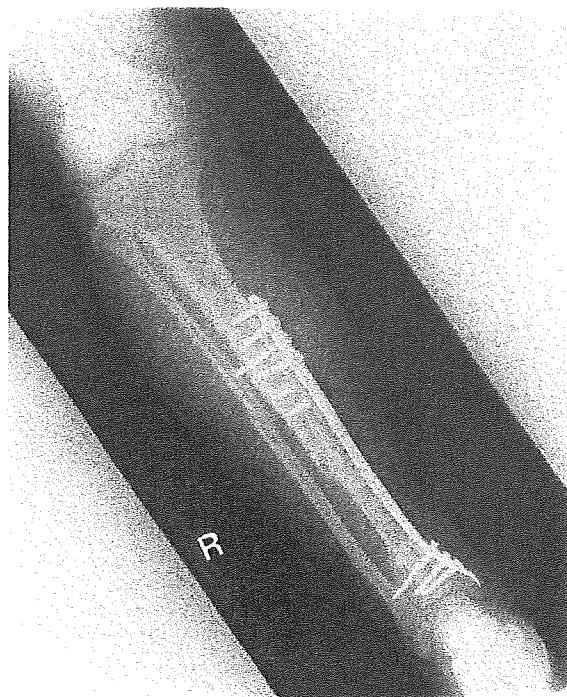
Eleven months postoperative, x-ray of the right lower leg showed good union between the grafted bone and the recipient bone.
